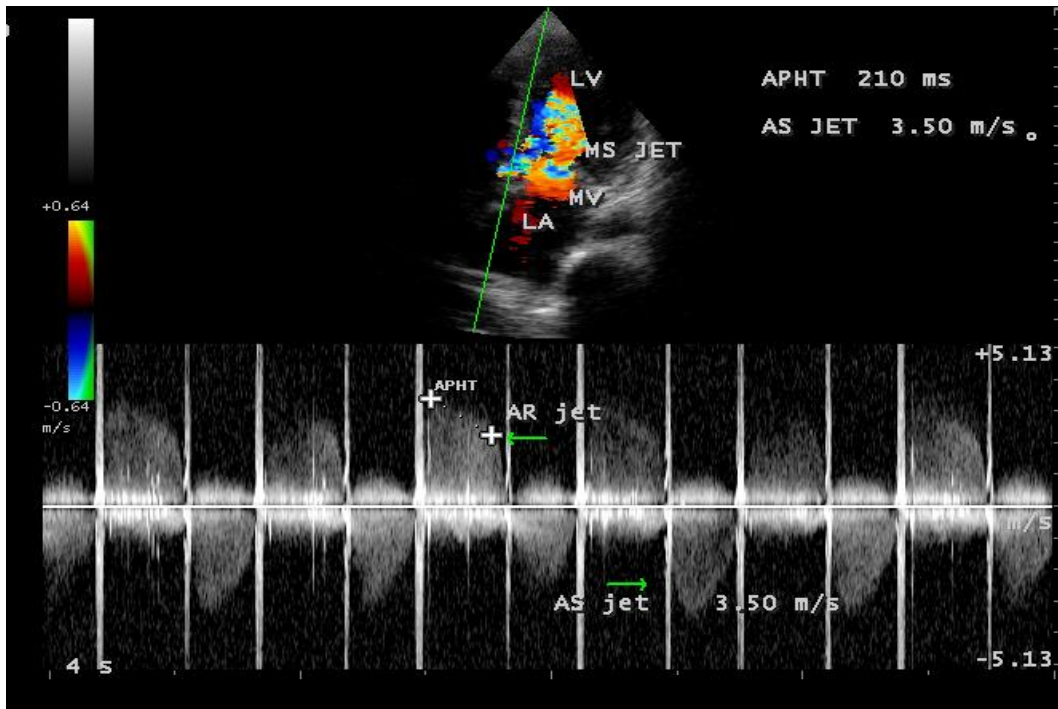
CW (continuous wave) Doppler showing the jets of aortic stenosis and regurgitation in a 34-year old male.
